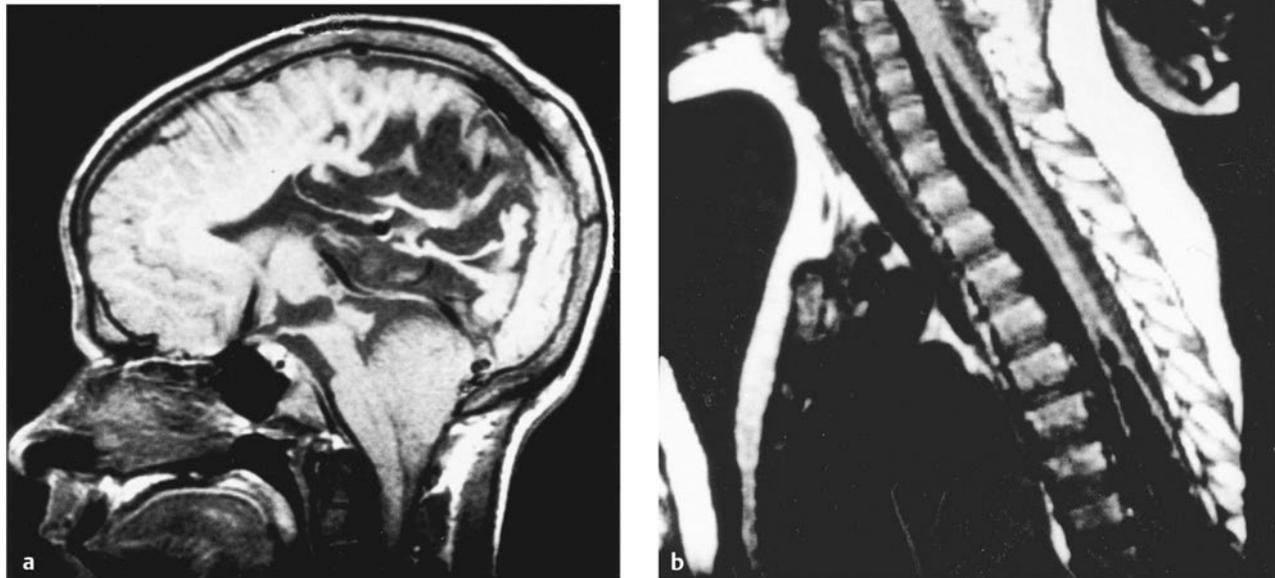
Chiari 2 malformation and syringomyelia. (a) Midsagittal T1-weighted magnetic resonance (MR) image shows disordered sulcation of the posterior cortex (stenogyria), dysgenesis of the corpus callosum, beaked tectum, and enlarged massa intermedia of the thalamus. The cerebellar vermis and brainstem lie below the foramen magnum. (b) Midsagittal T1-weighted MR image showing descent of the cerebellar vermis and brainstem below the foramen magnum and two syringes in the midcervical and thoracic regions.
